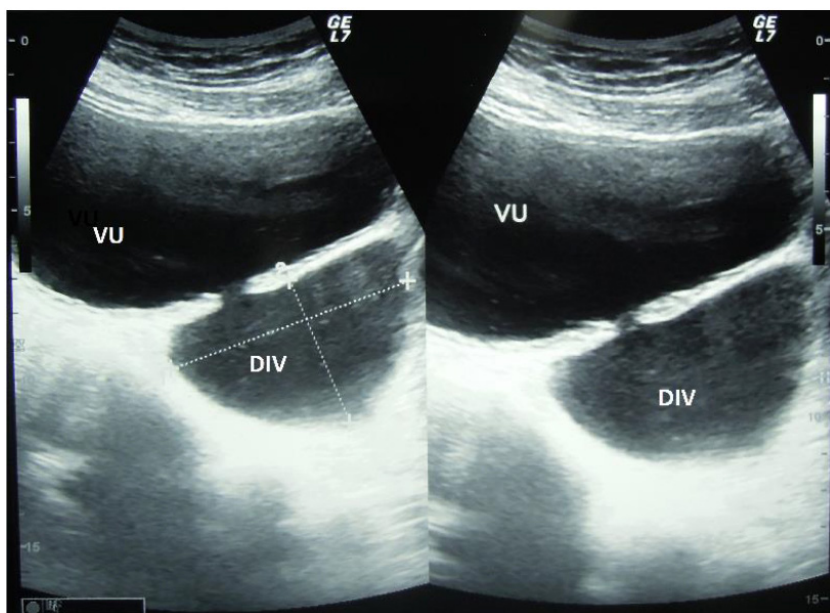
Ultrasonography showed bladder diverticula. VU: vesica urinaria, DIV: diverticula
